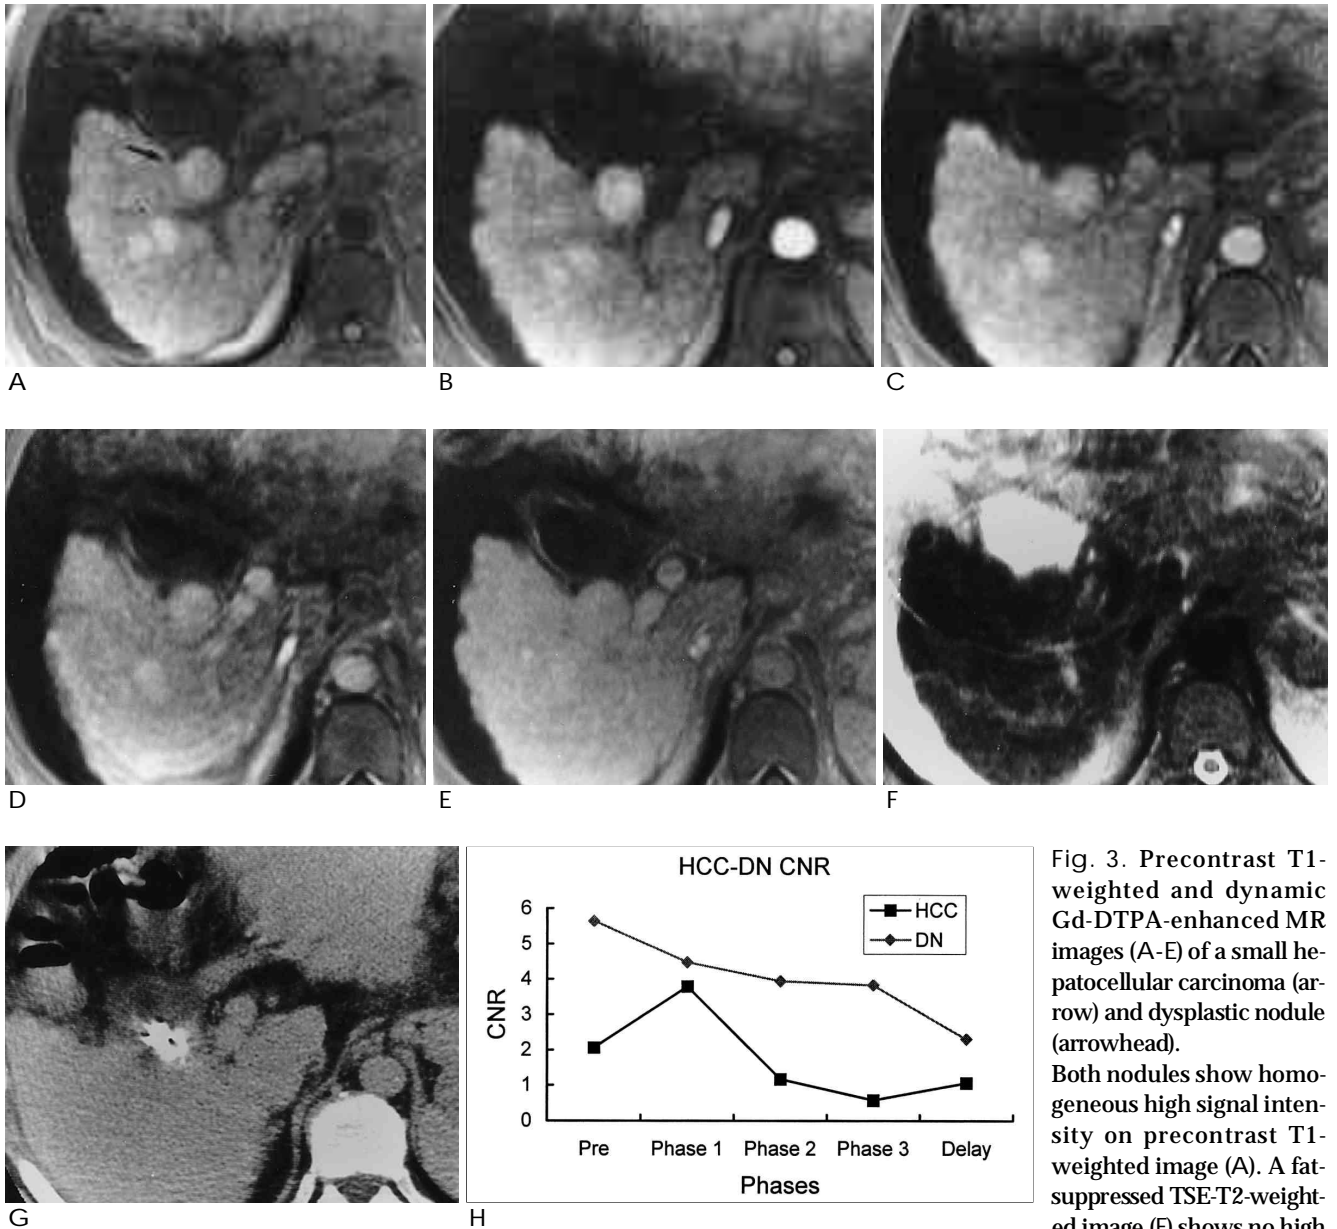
Precontrast T1-weighted and dynamic Gd-DTPA-enhanced MR images (A-E) of a small hepatocellular carcinoma (arrow) and dysplastic nodule (arrowhead). Both nodules show homogeneous high signal intensity on precontrast T1-weighted image (A). A fat-suppressed TSE-T2-weighted image (F) shows no high signal intensity for these nodules. The degree of visual enhancement is not overt on dynamic study (B-D) and there is no contrast wash-out or capsular enhancement on delayed image (E). However, the CNR versus phase curve shows a rapid increase in CNR at phase 1 in small hepatocellular carcinoma (H) correlated with lipiodol CT scan (G) and no peak of CNR in dysplastic nodule (H).
